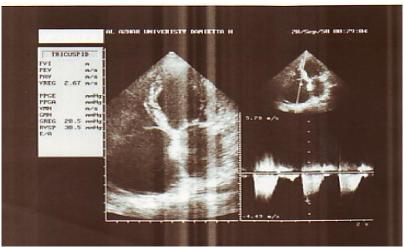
ECHO studied fore female patient, 50 years, with RA since 7 years showing Apical four chamber view showing pulmonary hypertension (50 mmHg).
